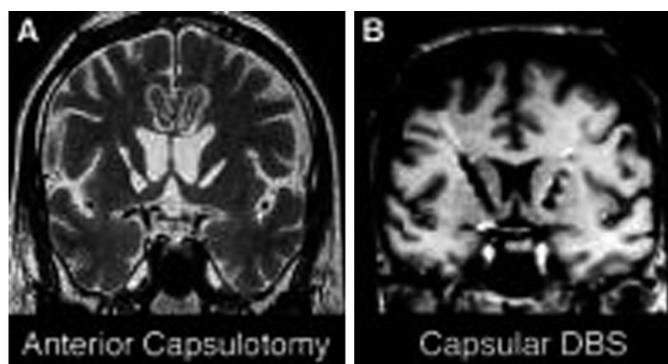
(A) Coronal T2-weighted image showing the lesion location in the anterior internal capsule for a capsulotomy using thermocoagulation. Reprinted from *Neurosurgery clinics of North America*, 14, 267–274, Copyright 2003,³¹⁴ with permission from Elsevier. (B) Coronal T1-weighted image showing the location of stimulating electrodes for deep brain stimulation (DBS) in the same location. Reprinted with permission from Lipsman *et al.* Deep brain stimulation for treatment refractory obsessive-compulsive disorder: The search for a valid target. *Neurosurgery* 2007; 61: 1–11.¹¹²
